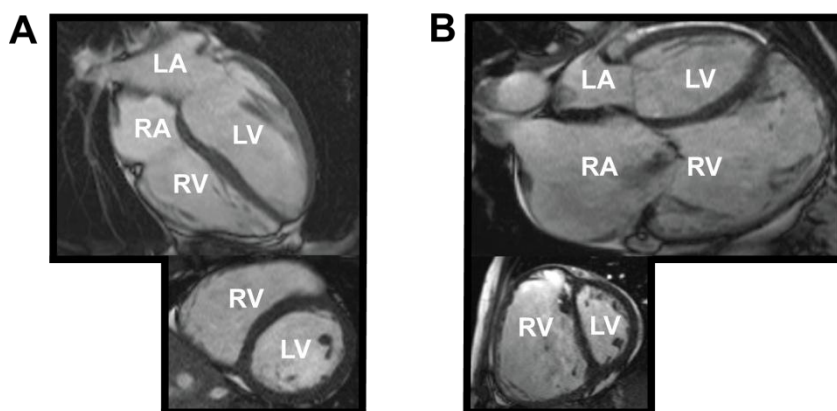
Magnetic resonance imaging (MRI) of the RV in a healthy individual and in a patient with PAH.
